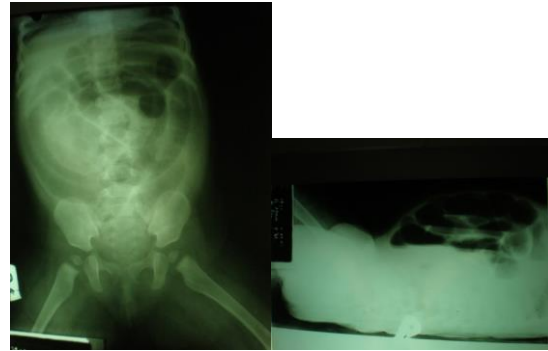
Abdominal X-ray
